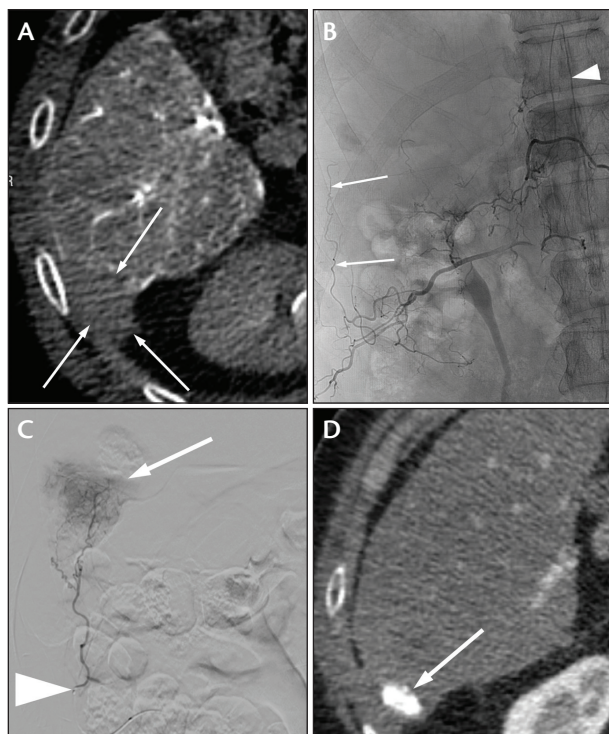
Cone-beam CT of the right hepatic artery demonstrated a paucity of artery supply (A, arrows) to an LI-RADS category 5 HCC in a patient who had received previous chemoembolization. Multiple intercostal and lumbar arteries were interrogated using angiography until the 12th intercostal artery that supplied the tumor was identified (B, arrows). Note the artery of Adamkiewicz arising from the proximal portion of the 12th intercostal artery (B, arrowhead). Advancing a microcatheter distally (C, arrowhead) into the branch supplying the tumor (arrow) allowed for safe administration of TACE. Follow-up CT showed retention of ethiodized oil in the treated tumor (D, arrow) corresponding to the area of nonperfusion identified on the original cone-beam CT Scan.
